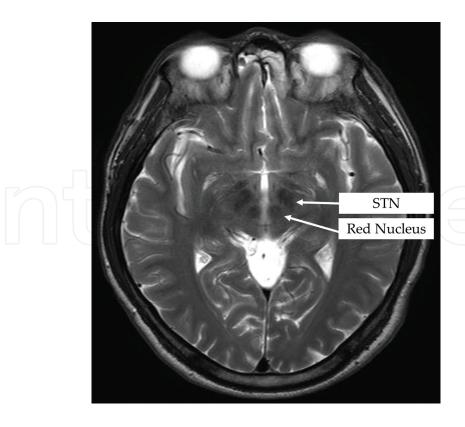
T2-weighted axial MR image indicates red nucleus and subthalamic nucleus.
